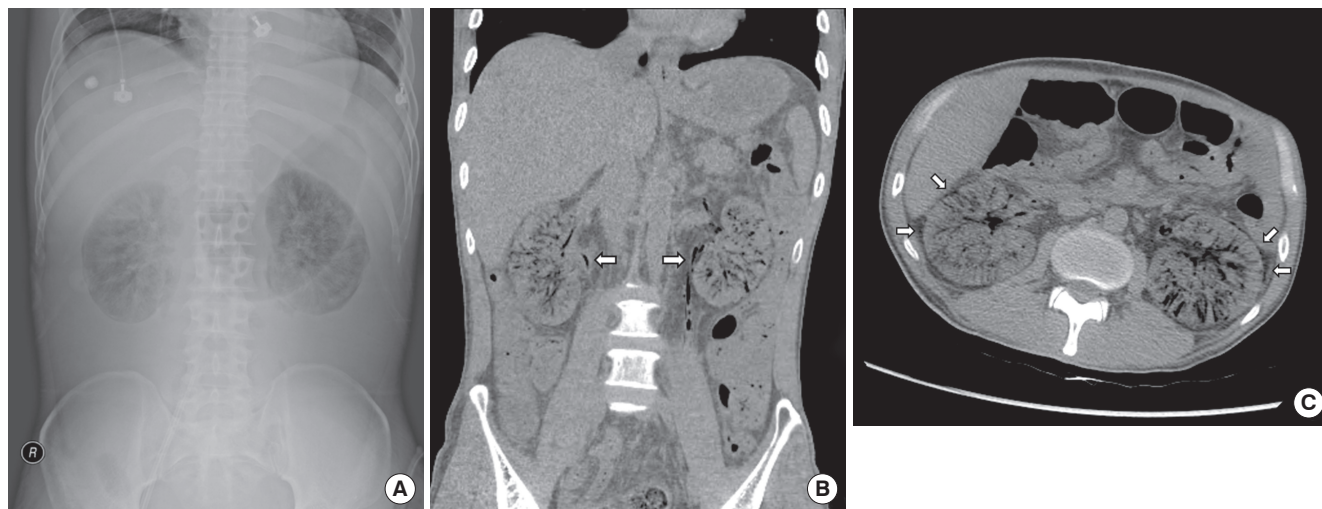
Radiological findings of bilateral emphysematous pyelonephritis. (A) Plain abdomen showed extensive gas collection, (B) computed tomography scan showing gas collection in both ureters (arrows), and (C) extensive intraparenchymal and perinephric gas collections in both kidneys (arrows).
